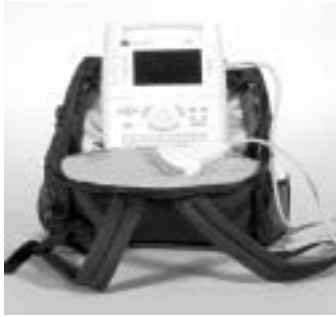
Typical sonography device.
